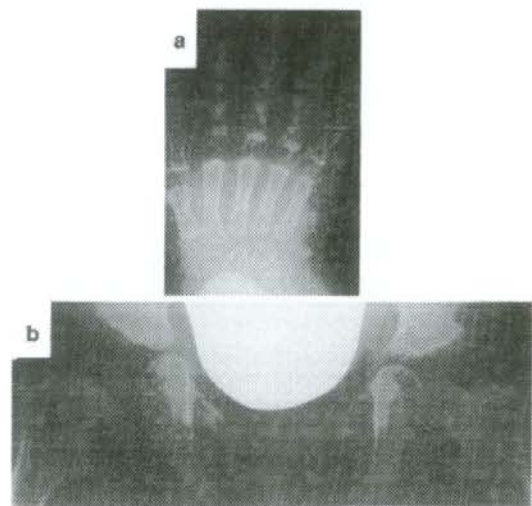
X-rays at 7 months of age. a Metacarpal bones and phalanges were broad. Four carpal bones were visible, indicating that carpal bone ossification was advanced. b Swedish-key appearance of proximal femora were visible
